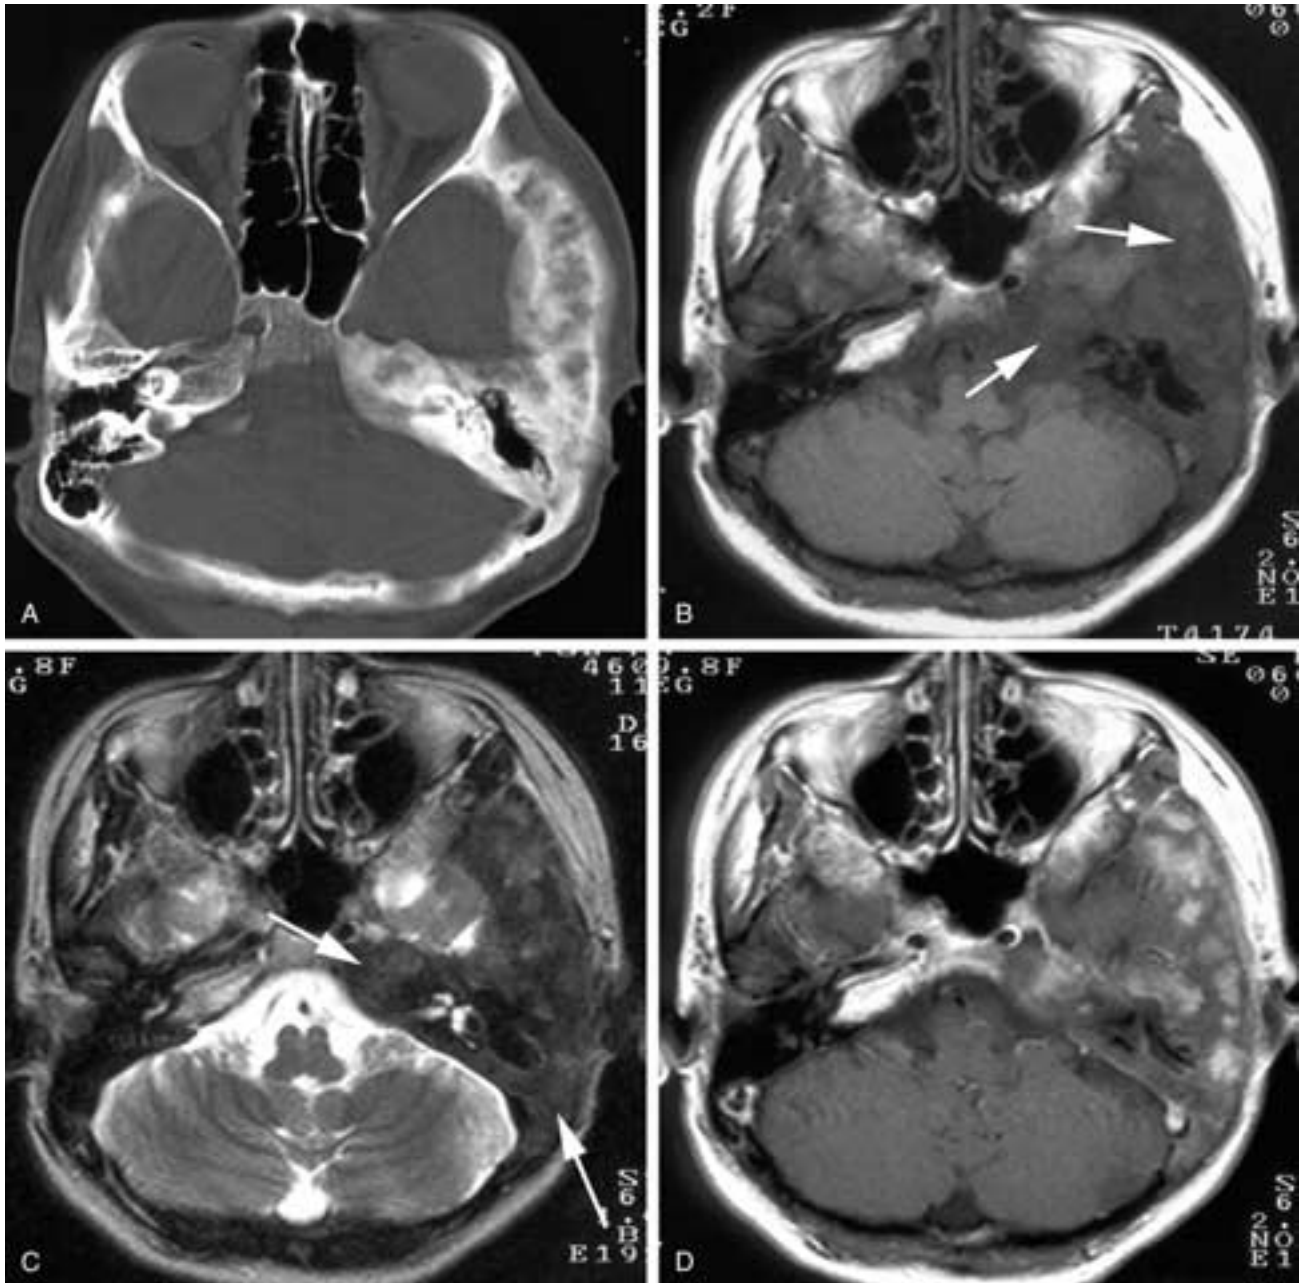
Fibrous dysplasia. A, Axial CT image shows the expansile pagetoid form of fibrous dysplasia of the left temporal bone. B, Axial T1-weighted image shows the intermediate signal intensity (arrows) of the bony enlargement. C, T2-weighted image shows relatively low signal intensity with expansion of the bone (arrows). D, After contrast there is patchy enhancement of the abnormal bone.
